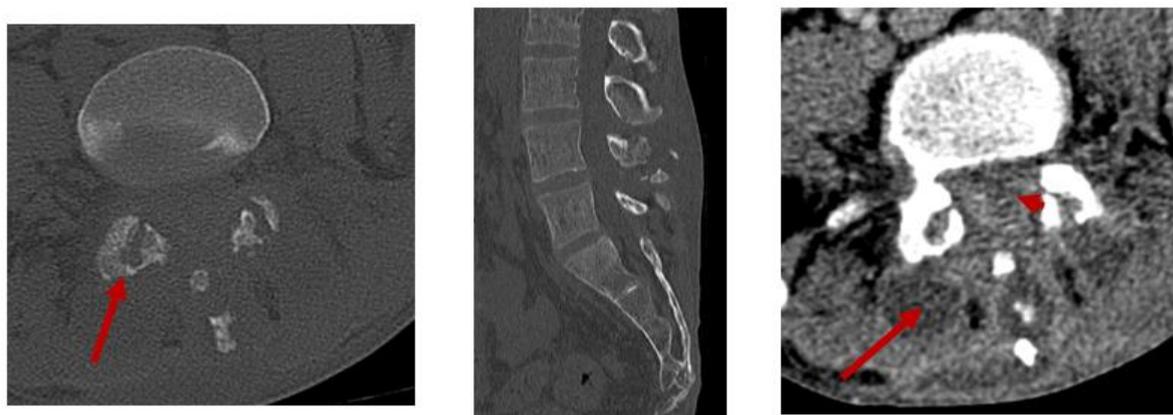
Lumbar CT scan without and with PDC injection: Osteolytic process involving the posterior vertebral arch of L5, hypodense, enhanced in the periphery after PDC injection (arrow), associated with bilateral epiduritis (arrowhead)
